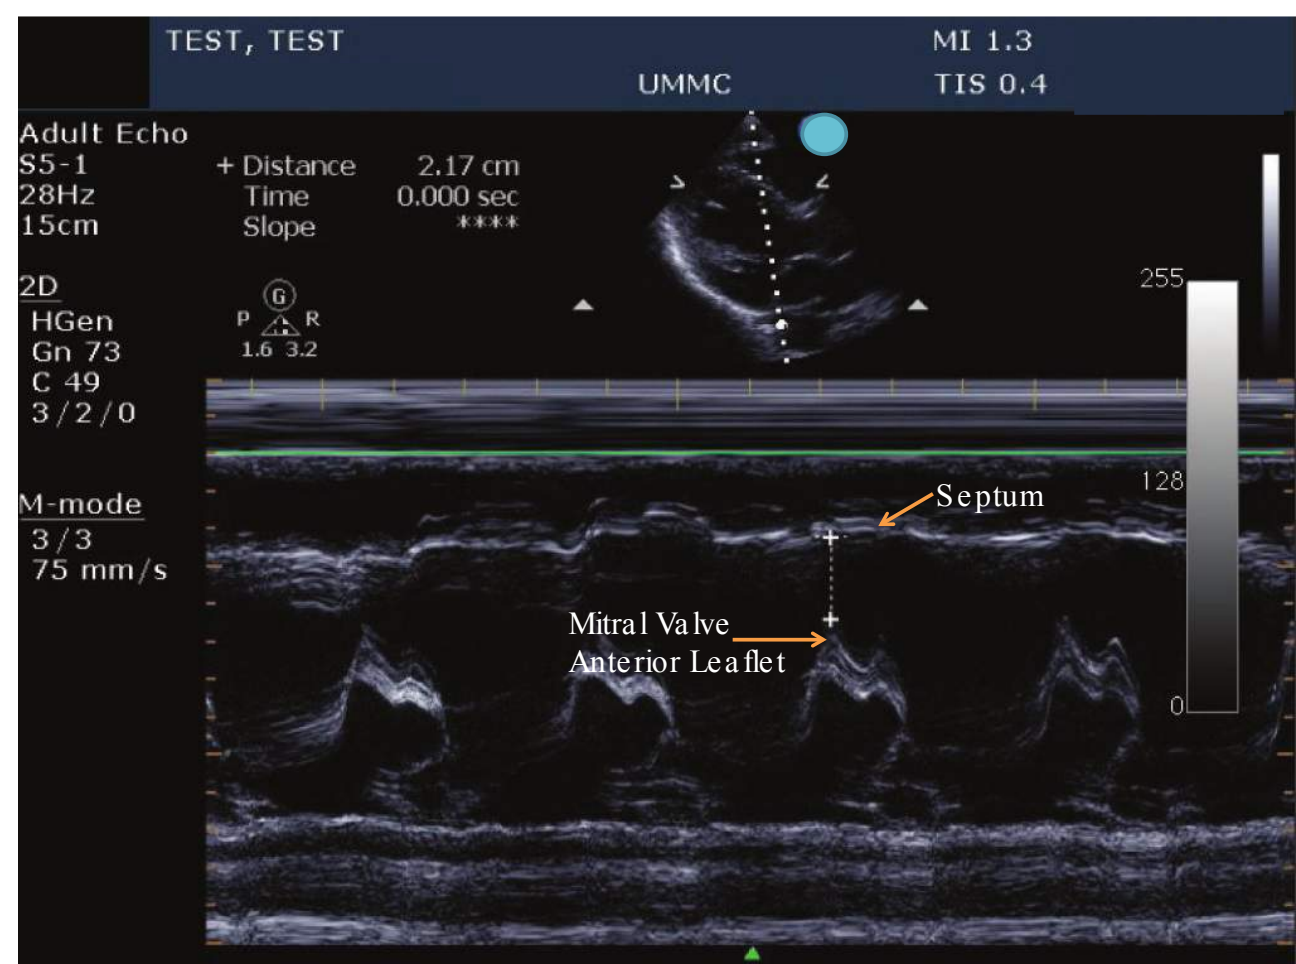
Parasternal long window with M-mode spike at the tip of the mitral valve anterior leaflet. The minimum distance from the septum to the anterior leaflet, or end-point septal separation (EPSS) is used to calculate ejection fraction (EF).
